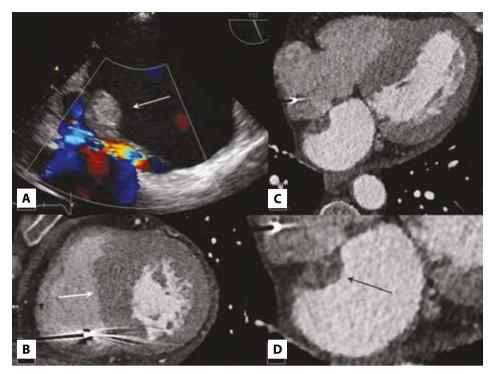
Patient 1. A. Transesophageal echocardiography. The white arrow shows a tumor attached to the interatrial septum in the left atrium, near the patent foramen ovale. B–D. Computed tomography. B. Short axis view. White arrow indicates hypertrophic interventricular septum. C. Four-chamber view. D. Magnification of panel C with focus on the left atrium. White arrow indicates tumor in the left atrium attached to the interatrial septum
